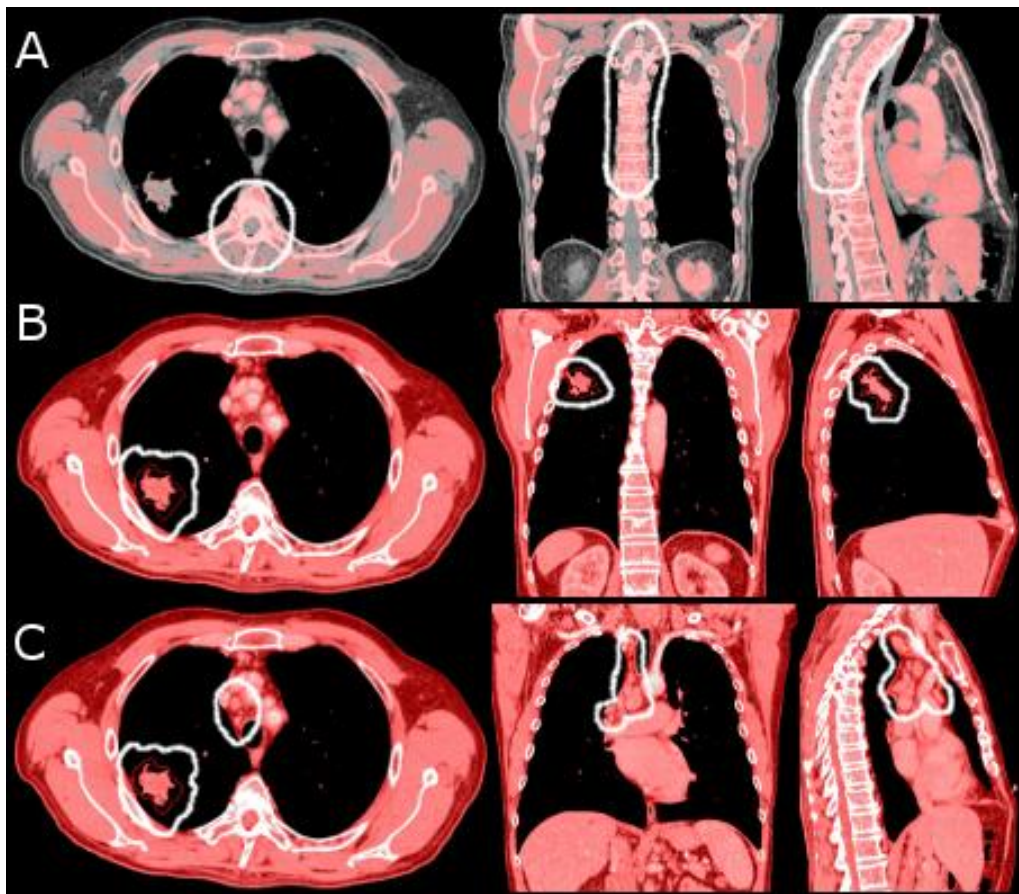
The different match VOIs presented on the DIBH CT image of patient 12. The white lines represent the match VOIs when performing (A) automatic bony match on the spine, (B) automatic soft-tissue match on GTV-T, and (C) automatic soft-tissue match on GTV-Total. The volume within the VOIs utilized for the registrations are colored red (i.e. pixels with an intensity range of [50; 3000] HU for bony match (A), and [-150; 150] HU for soft-tissue match (B and C)). Color version of figure is available online.
